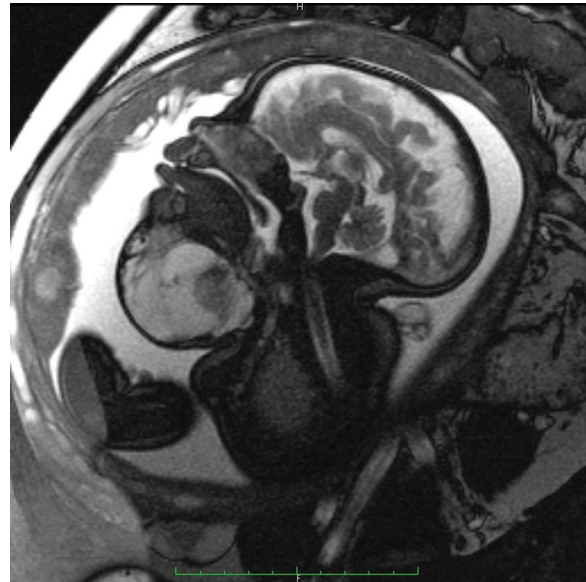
Fetal magnetic resonance imaging shows a large lymphatic malformation in the floor of the mouth and tongue. The head of the fetus is up with the nose pointing to the left. Planning for the management of the airway by a multidisciplinary team was required. The child was born by an ex utero intrapartum treatment (EXIT) procedure using maternal fetal circulation as a bridge to securing the airway. Although the child was successfully intubated during the EXIT procedure, a tracheotomy was inserted as the diffuse lymphatic malformation was found to also involve the supraglottis, which caused severe airway dysfunction.
